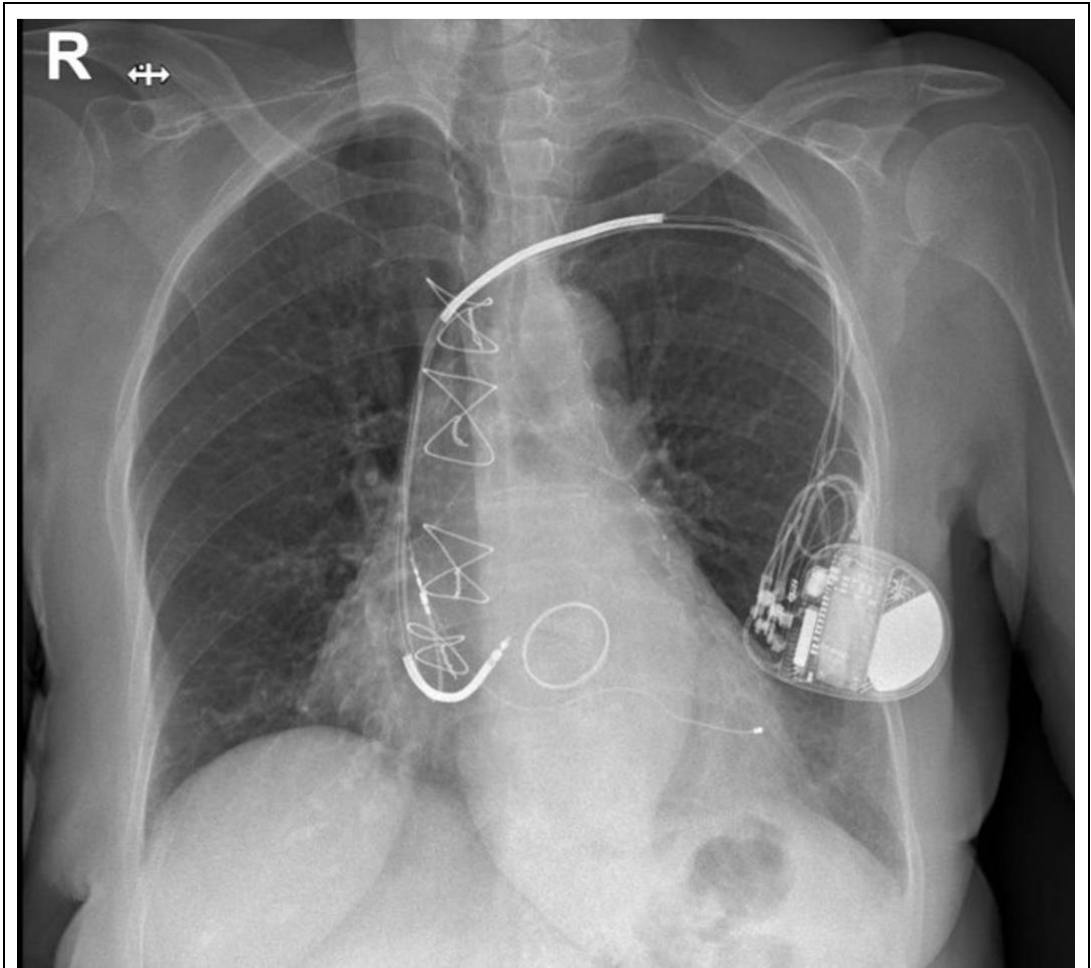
(Patient 2, Preoperative Chest Radiograph): Preoperative chest radiograph demonstrating the implanted pulse generator and transvenous leads in situ.
